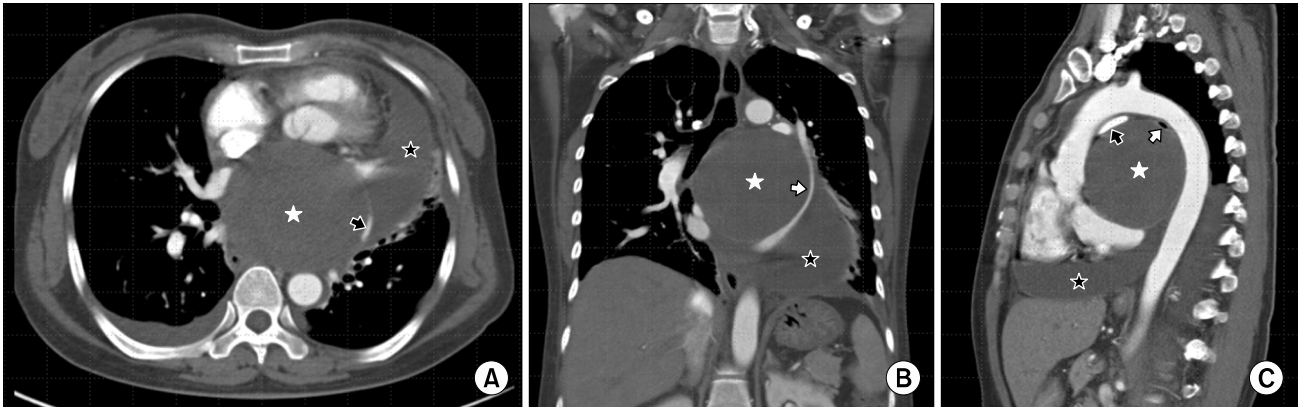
(A) Computed tomography of the chest shows a very large bronchogenic cyst (white asterisk) compressing the heart and a large amount of pericardial effusion (black asterisk). The left superior pulmonary vein was compressed by a bronchogenic cyst and the distended pericardium (black arrow). (B) A coronal image shows a better view of the compressed left superior pulmonary vein (white arrow). (C) The right pulmonary artery (black arrow) and left main bronchus (white arrow) were compressed by a bronchogenic cyst and the aorta.
